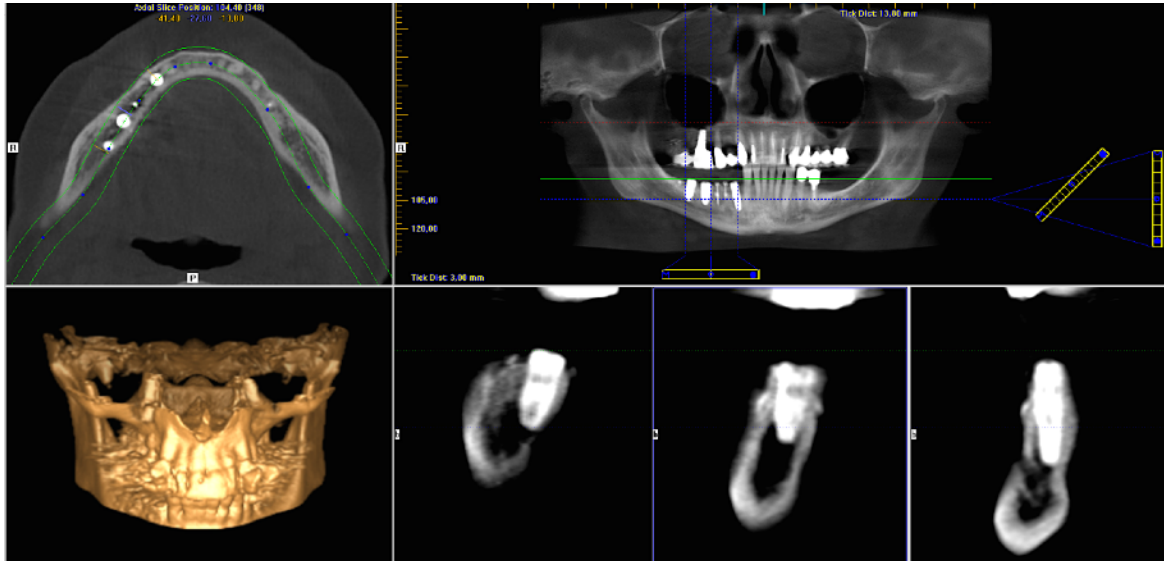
Long term radiographic follow up of crestal bone maintenance.
